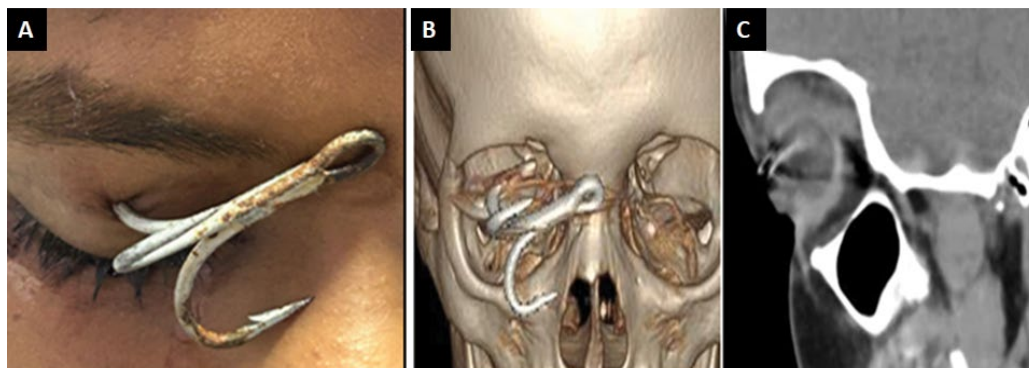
(A) Clinical photograph showing fish hook penetrating the globe; (B and C) CT scan showing penetration of the globe.
